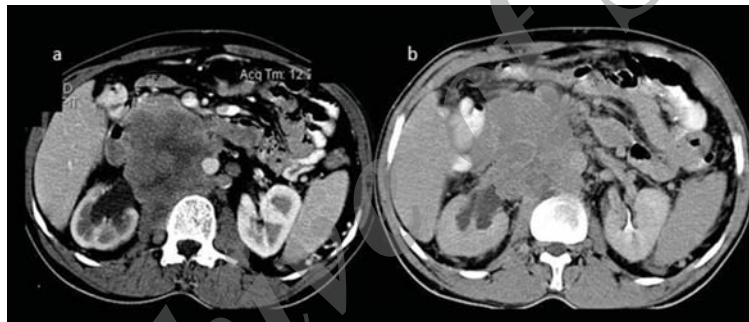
A 62-year male presented with backache for a period of 2 months. Postcontrast axial CT scan; a) Reveals a heterogeneously enhancing centrally necrotic tumor involving the segment II of IVC. The tumor infiltrates the posterior wall of duodenum and encases the abdominal aorta. Postcontrast axial CT; b) Reveals the sarcoma encasing the right renal hilum. Tumor thrombus is also seen involving the right renal vein. The excretion of contrast by the right pelvicalyceal system is delayed. Perisplenic collaterals are also seen.
